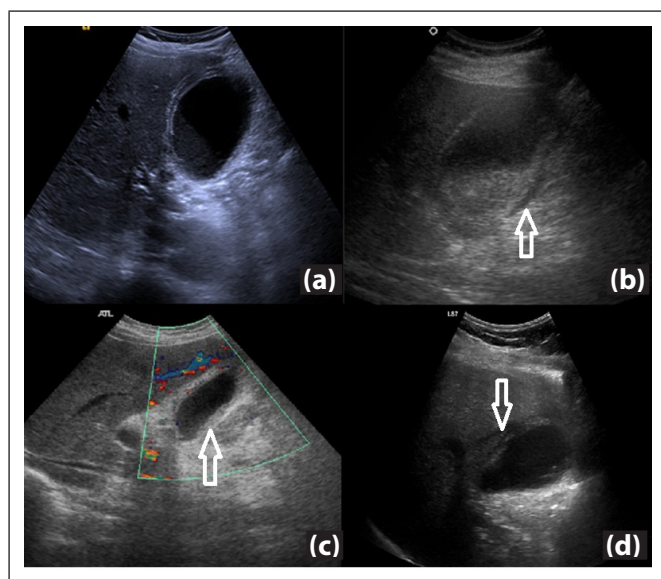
Representative preoperative ultrasound images of patients converted from laparoscopic to open cholecystectomy. Panels show a hydropic gallbladder with echogenic sludge (a), a hydropic gallbladder with pericholecystic fluid collection (arrow) (b), diffuse gallbladder wall thickening greater than 4 mm (arrow) (c), and a perforated gallbladder with focal discontinuity of the anterior wall and adjacent fluid collection (arrow) (d).
